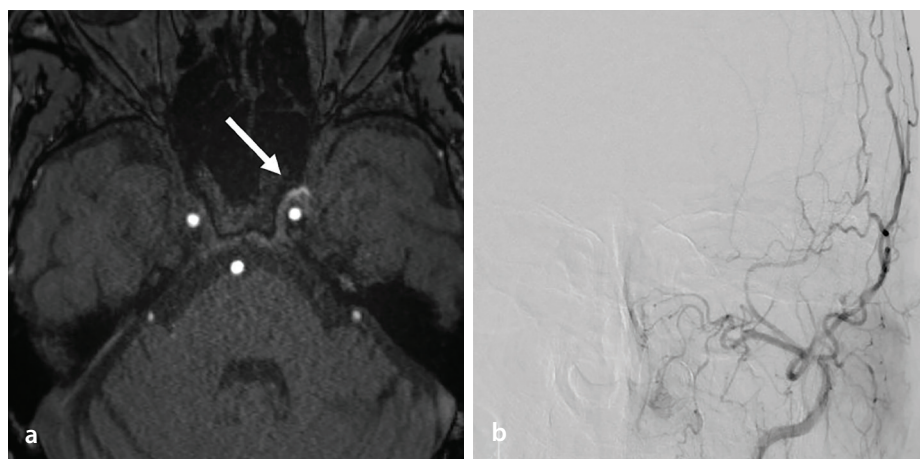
A 56-year-old man presenting with headache, in whom MRI raised suspicion of a left cavernous sinus DAVF. On the TOF-MRA source image (a), abnormal signal was noted around the left cavernous sinus (arrow), without enlargement of the middle meningeal artery. On DSA performed for further workup (b, left external carotid artery injection), no definite arteriovenous shunting was identified, and the signal on TOF-MRA was attributed to physiologic venous flow within the cavernous sinus. MRI, magnetic resonance imaging; DAVF, dural arteriovenous fistula; TOF-MRA, time-of-flight magnetic resonance angiography; DSA, digital subtraction angiography.
